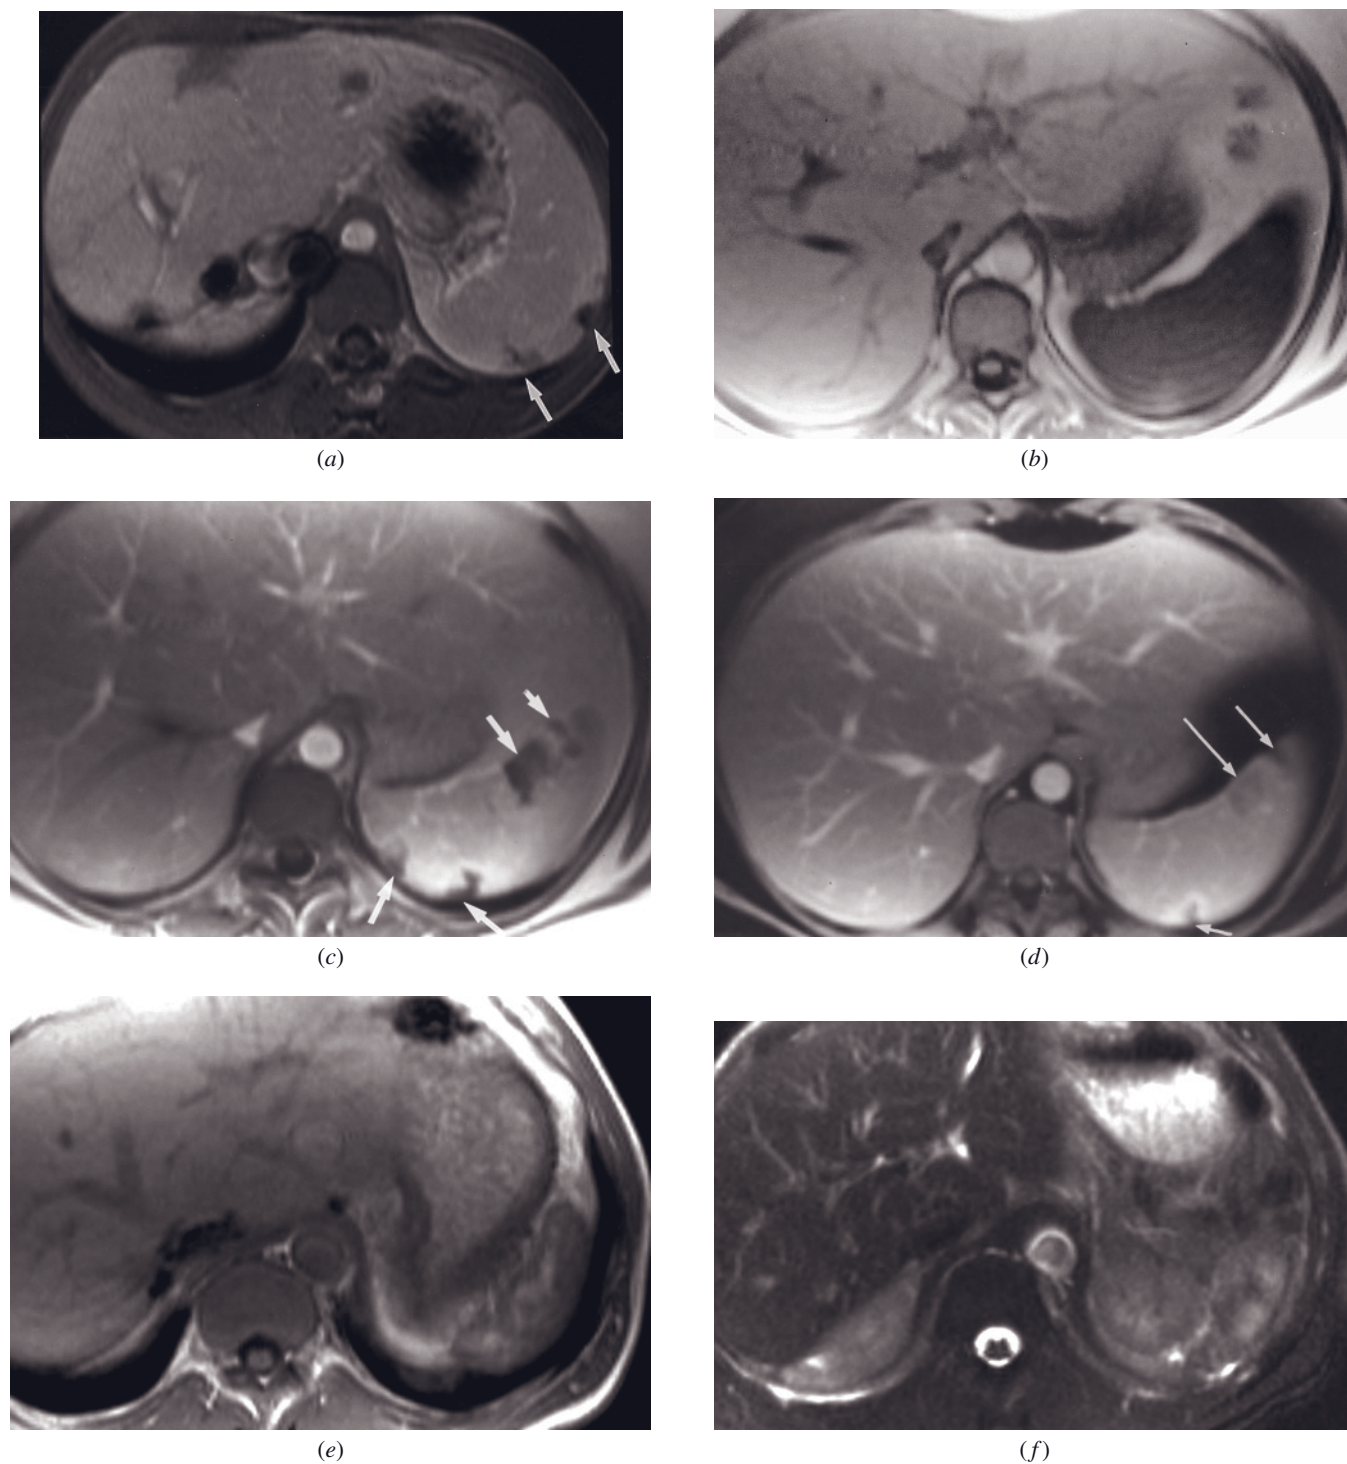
Splenic infarct. One-minute postgadolinium T1-weighted SGE image (*a*). Peripheral wedge-shaped defects are noted in the spleen (arrows, *a*) secondary to infarcts. T1-weighted SGE (*b*), immediate postgadolinium T1-weighted SGE (*c*), and 90-s postgadolinium T1-weighted fat-suppressed SGE (*d*) images in a second patient. An ill-defined posterior subcapsular hyperintensity is present on the T1-weighted image (*b*). Infarct regions are best seen on postgadolinium images (*c*, *d*) and appear as well-defined wedge-shaped defects (arrows, *c*, *d*). Peripheral linear enhancement of the capsule may also be appreciated. Note that some of the regions that have no enhancement on the immediate postgadolinium images show delayed enhancement. These are consistent with areas of ischemia. T1-weighted SGE (*e*), T2-weighted fat-suppressed single-shot echo-train spin-echo (*f*), immediate T1-weighted
